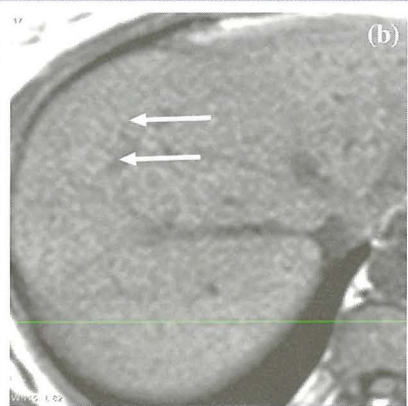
(a) Multifocal fat accumulation in the liver appears as hypodense foci on unenhanced CT scan in a 48-year-old woman with breast cancer who was misdiagnosed as liver metastatic disease on the basis of CT findings. T1-weighted GRE MR images show nodules (arrows) with signal intensity slightly higher than that of the normal liver parenchyma on the in-phase image (b) but with a signal intensity loss on the opposed-phase image (c); this confirms the diagnosis of multifocal fat accumulation.
